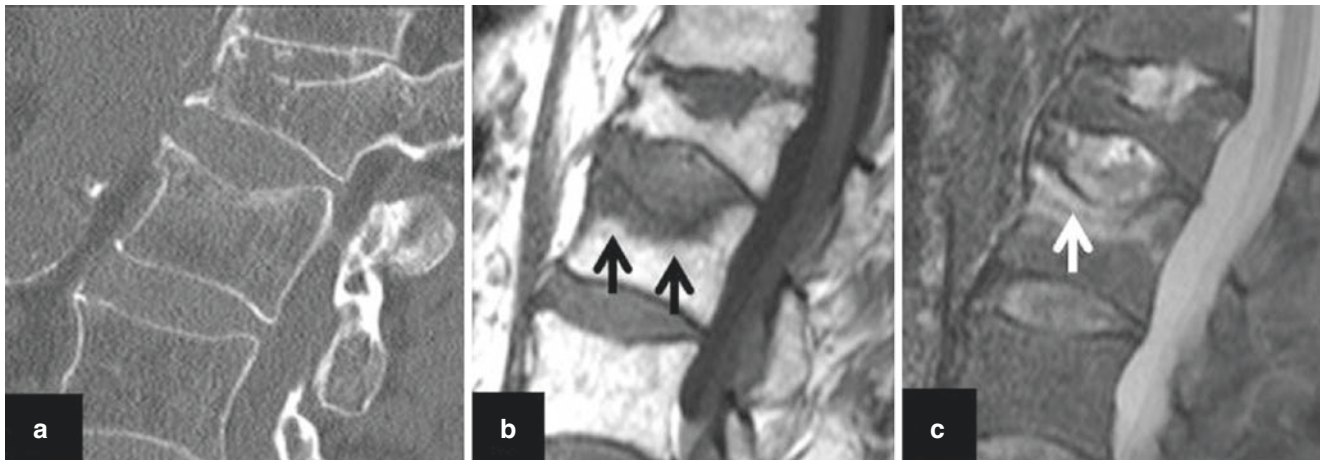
Osteoporosis and vertebral fracture in an 82-year-old woman. (a) Sagittal reformatted CT image of the upper lumbar spine shows L1 and L2 vertebral fractures. (b) Corresponding T1-weighted MR image shows decreased signal intensity of L2 (recent fracture)
